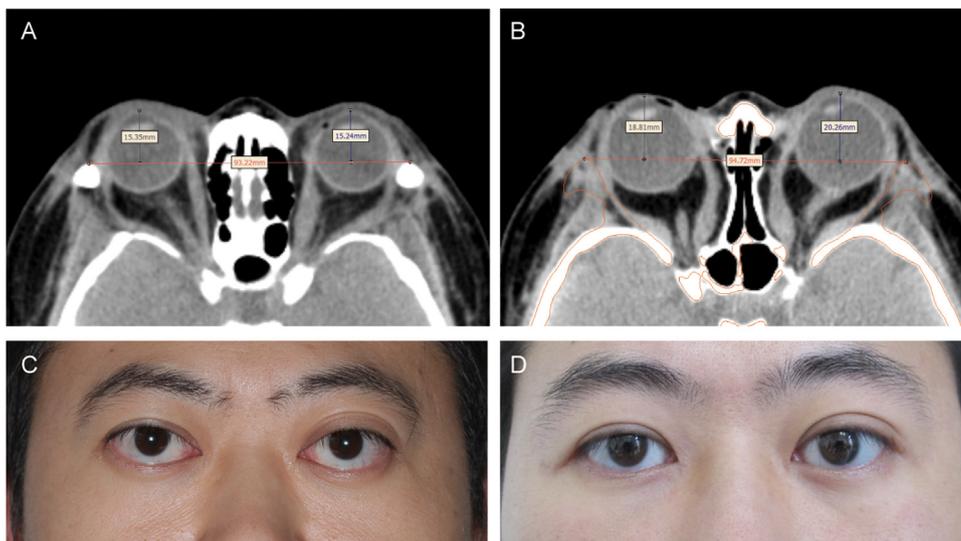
Measurement of proptosis based on CT images for (A) the rim-sparing technique, and (B) the rim-removal technique. For the rim-removal technique, the preoperative and postoperative CT images were digitally merged using Mimics 17.0 software (Materialise, Belgium). Reconstructed orbital bony structures and measurement lines (orange line) were provided for the measurement of proptosis. The photographs show a patient who underwent bilateral orbital decompression with the rim-sparing technique (C) preoperatively, and (D) and postoperatively.
